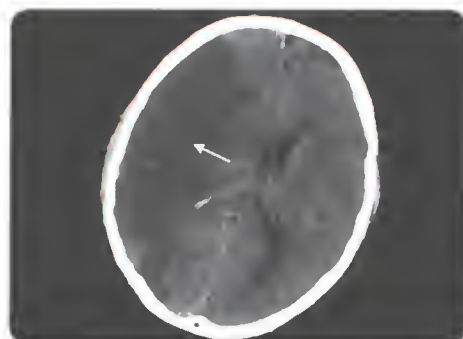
Axial section of computed tomography scan showing right ischemic stroke (arrow).
